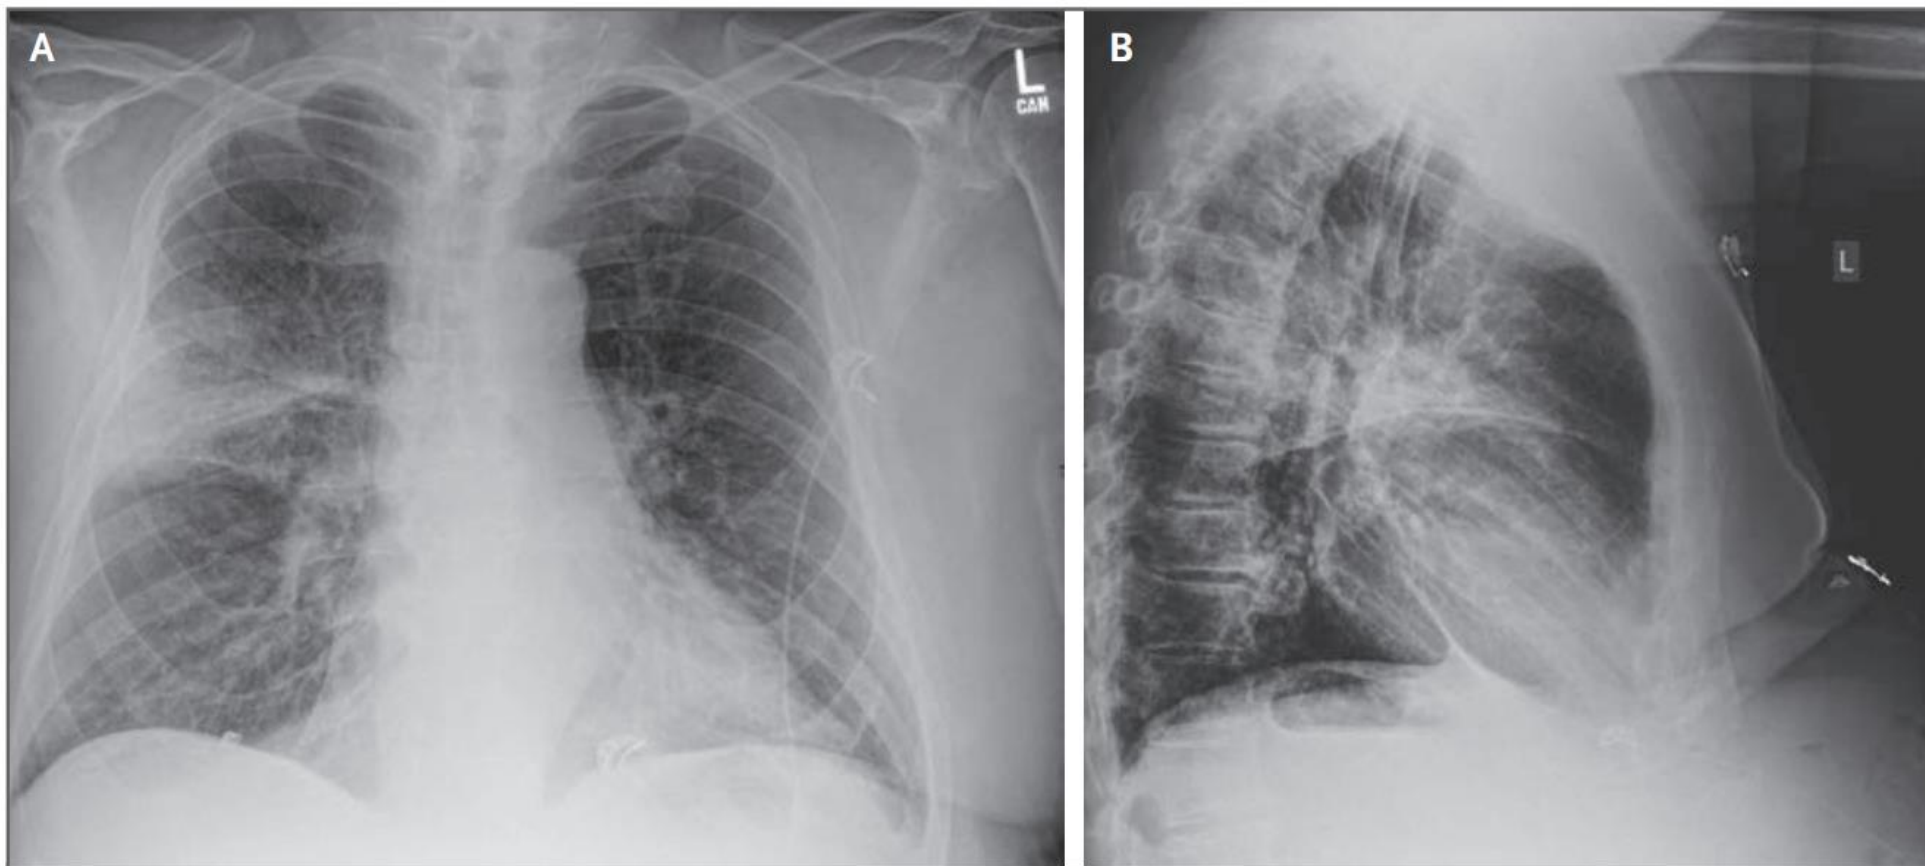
Chest Radiographs.
